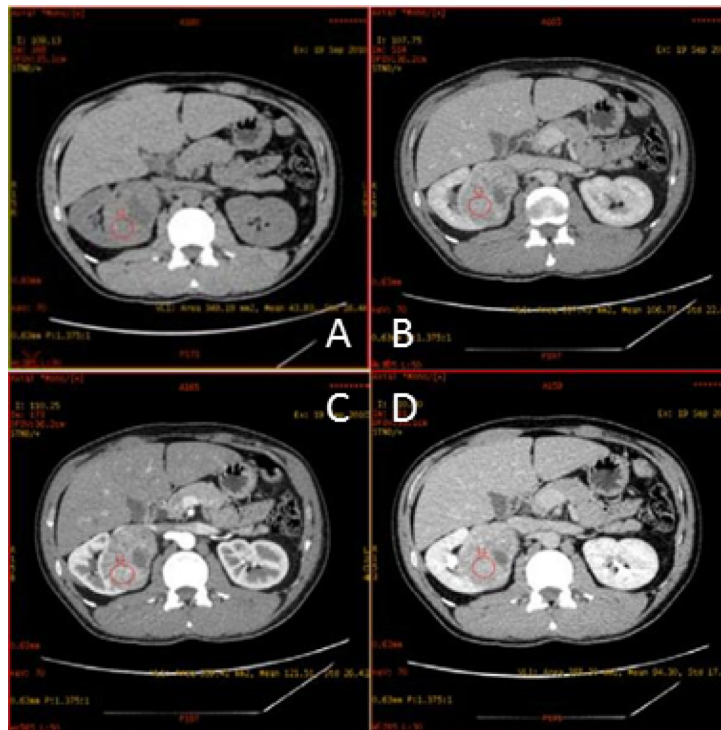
Transverse CT scans of a 34-year old man with AML in right kidney. Shown are (A) unenhanced scan; (B) corticomedullary phase scan showing mass with heterogeneous attenuation and containing no area with attenuation as low as that of perinephric fat; (C) nephrographic phase scan; and (D) excretory phase scan. The red circles are the region of interest (ROI).
